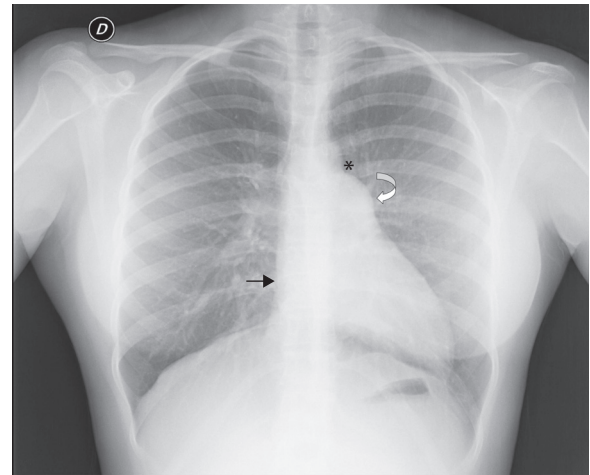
Posterior–anterior chest X-ray showing levoposition of the heart without tracheal deviation, right heart border superimposed on the spine (straight arrow), imprint of the main pulmonary artery (curved arrow), interposition of lung parenchyma between the aortic arch and left pulmonary artery (asterisk) and flattening and elongation of the left ventricular contour (Snoopy sign).
